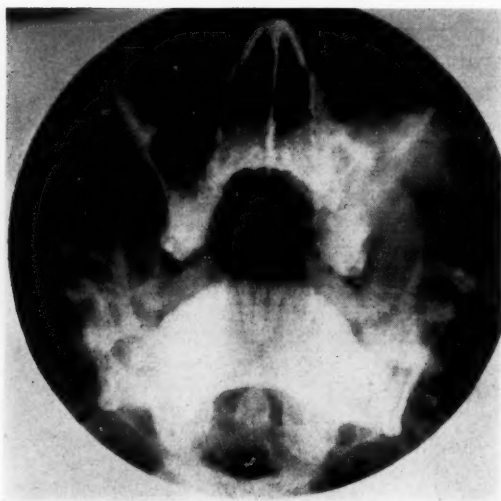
Roentgenograph of Case 2 showing dense mass replacing left antrum.
